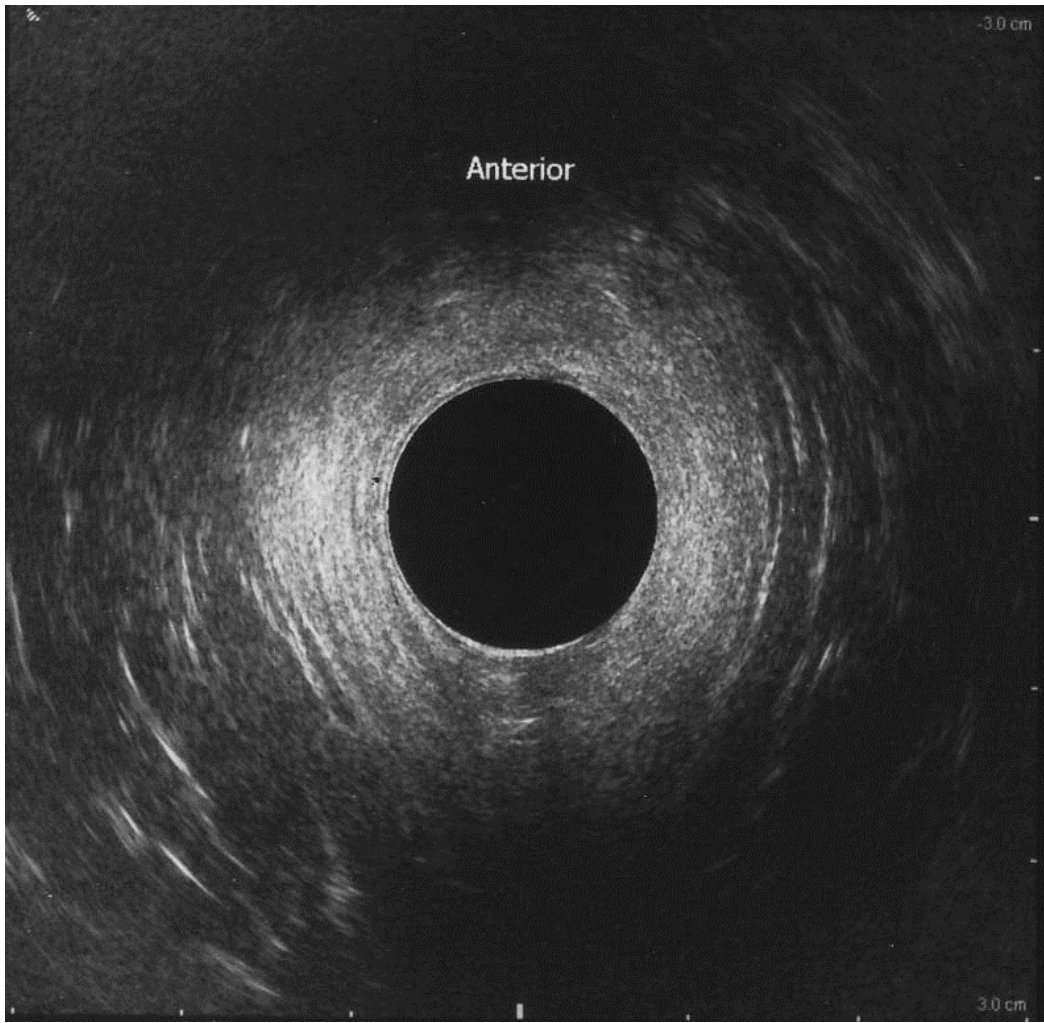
Normal ultrasound image of the superficial level of the anal canal
